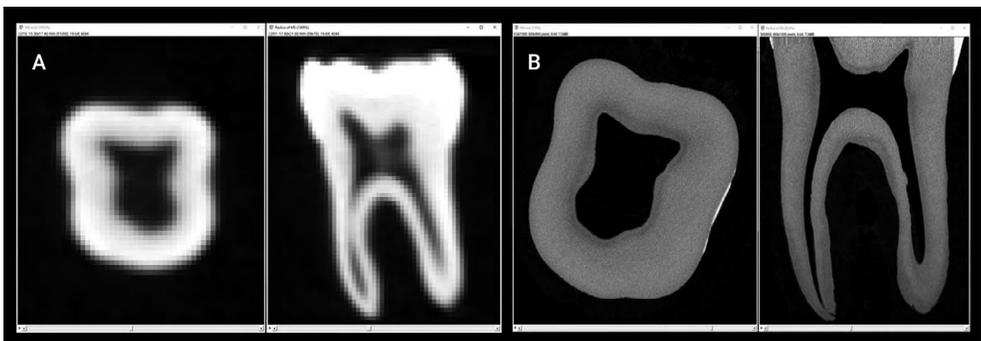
Image stacks visualized using ImageJ/Fiji software. Cone beam computed tomography (A); micro-computed tomography (B).
